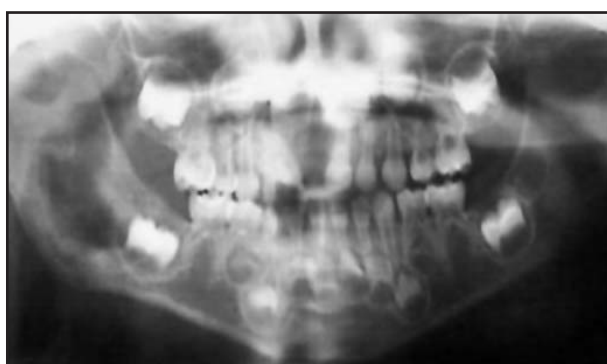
Panoramic radiograph of a child, four years of age, with single-system unifocal LCH. A single extensive radiolucent area, compatible with an osteolytic lesion, in mandibular ramus. Concentration of IL-1 β : 1866.08 pg/ml.
